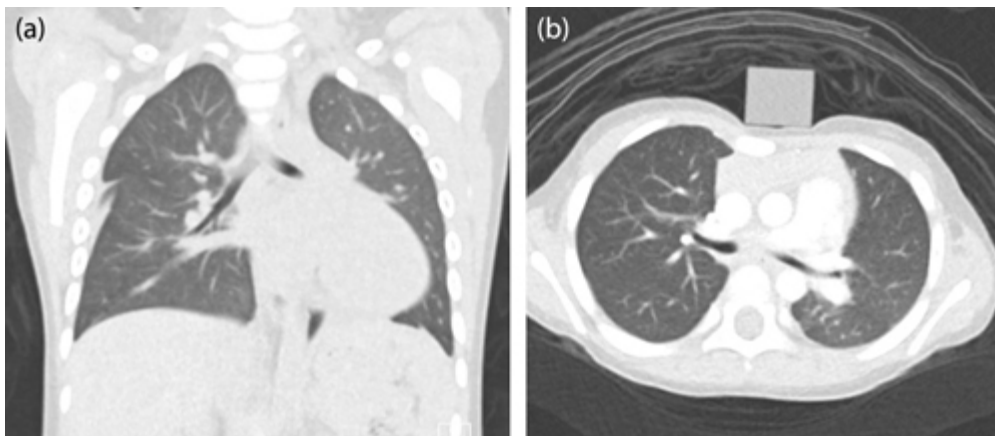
(a and b) Repeat CT thorax shows worsening Haller index with mild compression of the right atrium and ventricle with slight heart displacement to the left. The left main bronchus appears compressed with patchy areas of segmental pulmonary overinflation.
